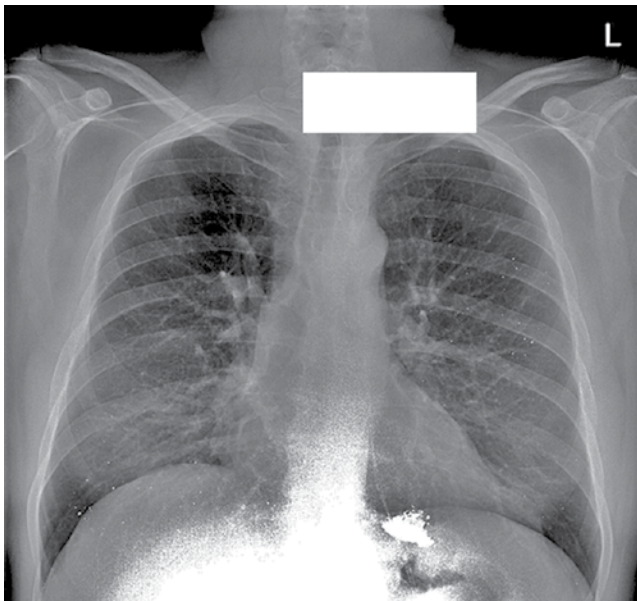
Chest x-ray showing high-density infiltrates throughout the lung fields.
